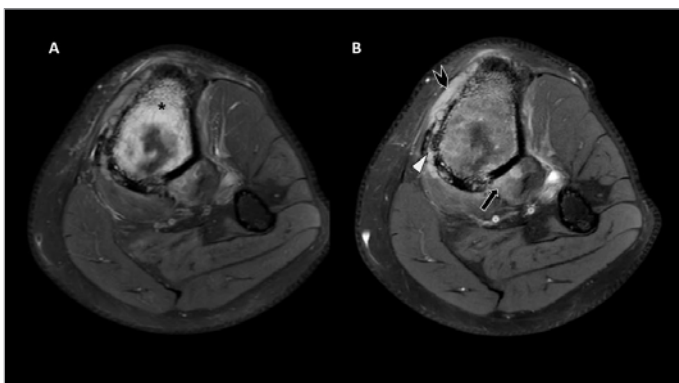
Bone lymphoma MRI.
